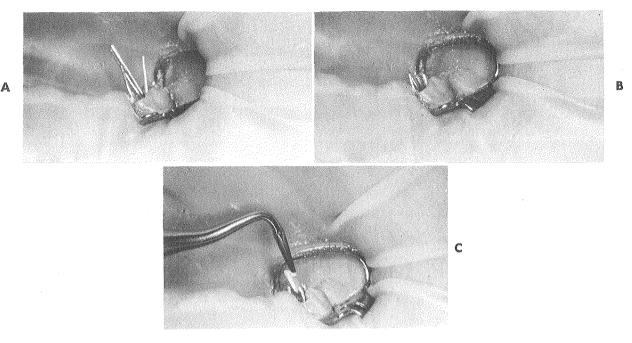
Steps in silver point obturation. A, Points are fitted into prepared root canals to calculated length, and a roentgenogram is used to determine their exact position. B, Roentgenogram indicates that three points are fitted properly and they are cut level with the highest cuspal point. Fourth point is 1 mm. short of apex and is cut to extend 1 mm. above other points. Then it is moved down flush with other points by enlarging and extending canal or by decreasing the diameter or point. Points are sealed into place with root canal sealer, and their exact position is determined again by a roentgenogram. C, Pulp chamber then is filled by condensing warm gutta-percha around silver points. Points are cut off level with pulp chamber roof, using a No. 37 high-speed bur.
